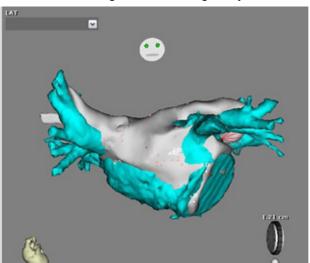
Electroanatomical reconstruction of the four pulmonary veins and left atrium. The electroanatomical map is fused with the computed tomography of the LA.
